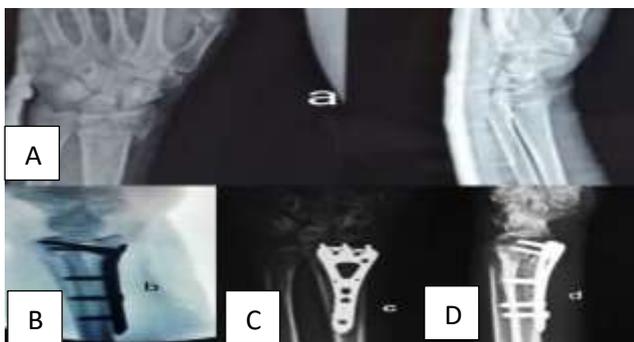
X-ray pictures of patient operated with variable angle volar locking plate.
